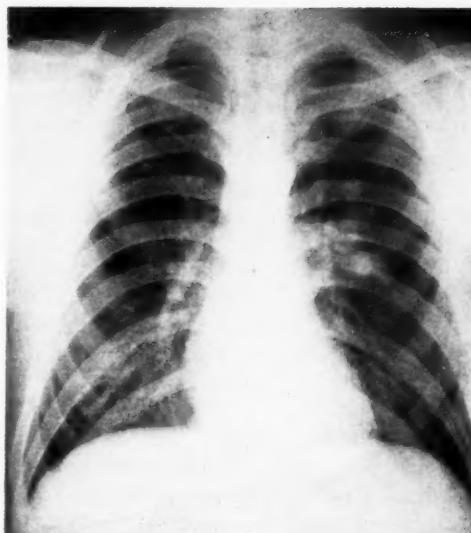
Case III. Postero-anterior roentgenogram of the chest shows numerous large cylindrical densities adjacent to the left hilus. Subsequent angiography demonstrated an arteriovenous fistula, but surgery was refused because of the probability of a pneumonectomy being required to eradicate the lesion.
